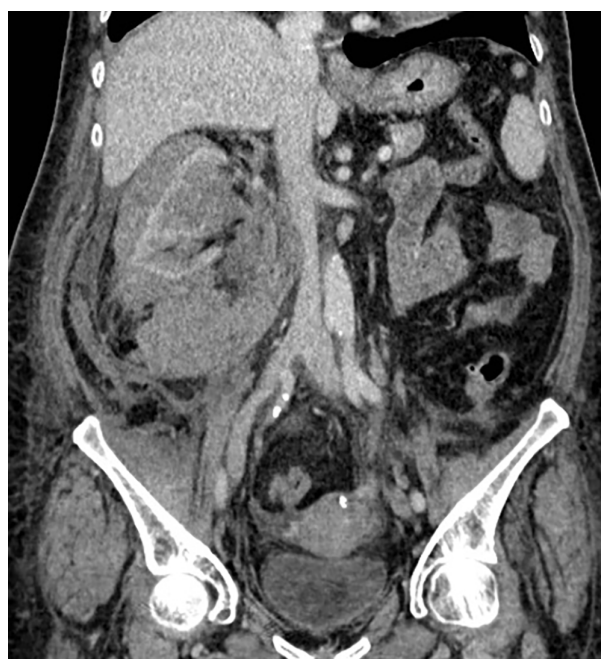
Enhanced CT image of the right kidney
